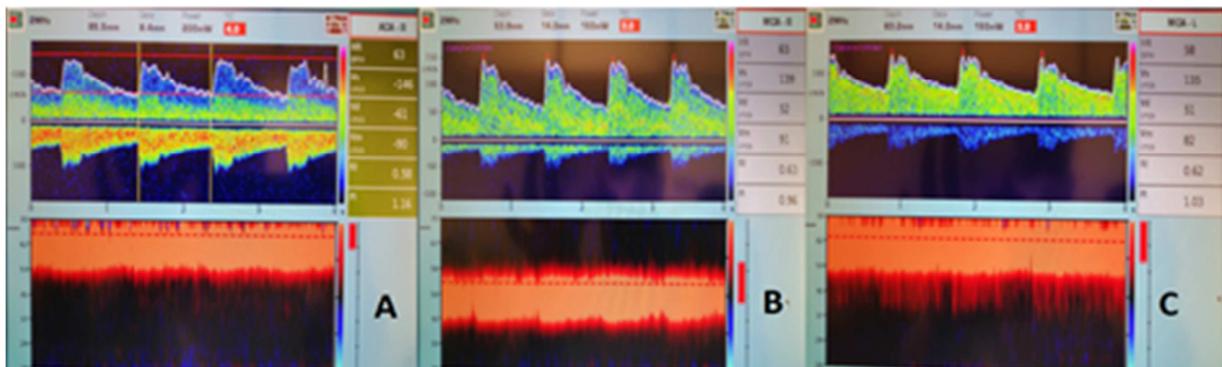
TCD ultrasound of high MFV (Mean flow velocity) in multiple arteries suggestive of moderate to severe stenosis.
